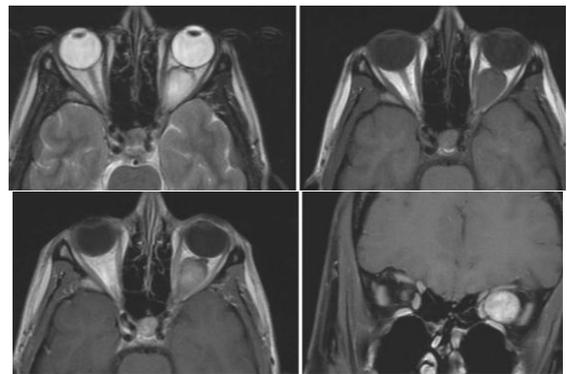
MRI of orbit (T2, T1 axial & coronal fat sat sequences) showing left optic nerve glioma.
